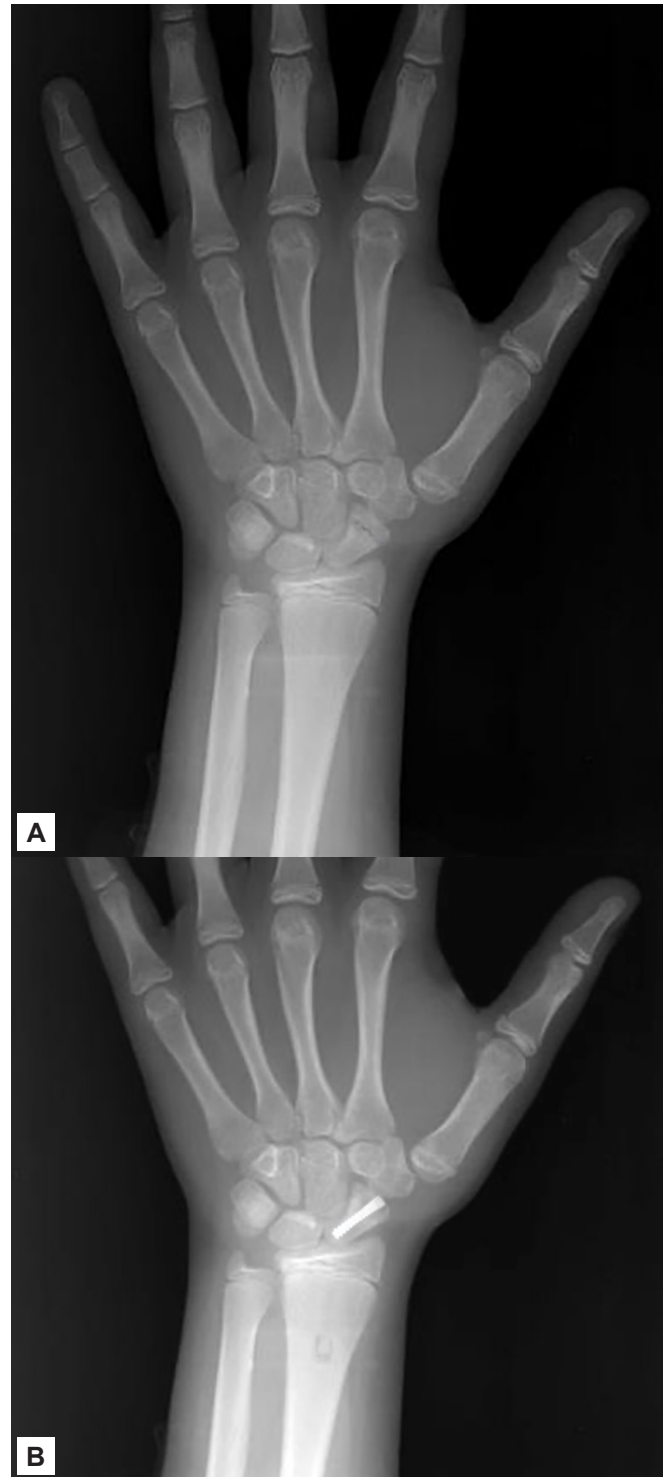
(A) Pre-operative x-ray of a 12-year-old male patient (Case 3) (B) Posterior-anterior x-ray at 1 year postoperatively.
